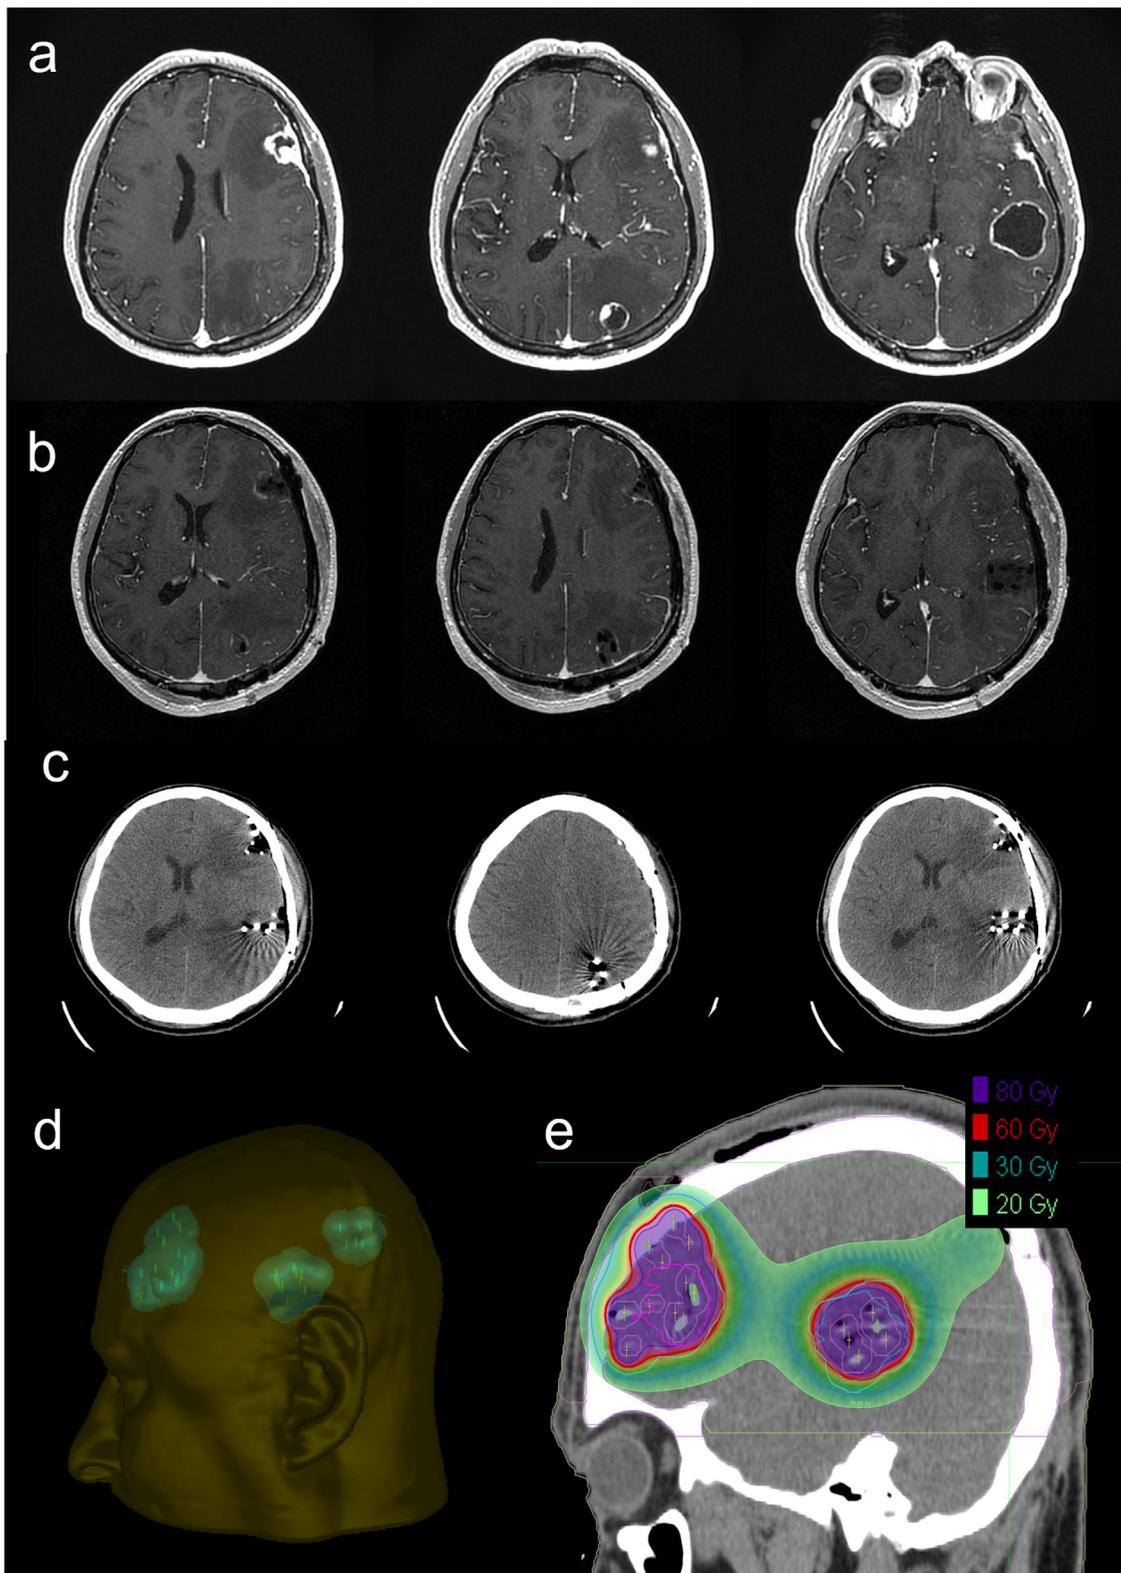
Simultaneous resection and GammaTile placement for 3 intracranial lesions that failed GK treatment. Magnetic resonance imaging T1+C of the left frontal (left), parietal (middle), and temporal (right) lesions immediately before (a) and after (b) surgery. (c) Noncontrasted computed tomography immediately postoperative. (d) Representation of the distribution of the cavities (green cloud) and ^{131}Cs seeds (green bars). (e) Dose clouds from GammaTile on a representative sagittal image.
